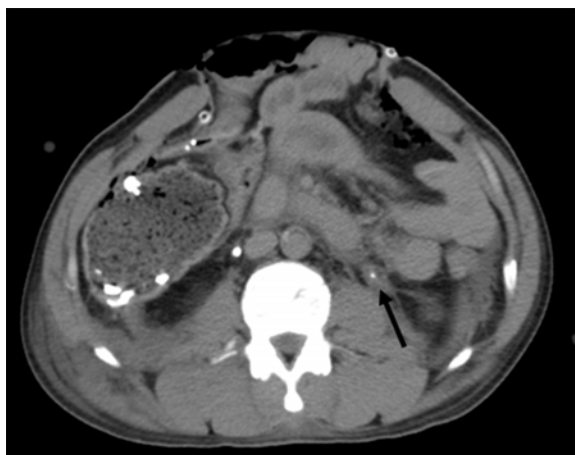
Grade 1 ureteric injury. A 46-year-old male presented with fall from height. Axial CT scan on delayed phase shows left ureteric wall thickening and periureteric hematoma (arrow) without gross contrast extravasation.
